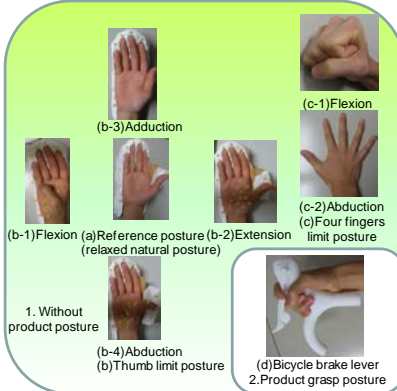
MRI measurement postures.
